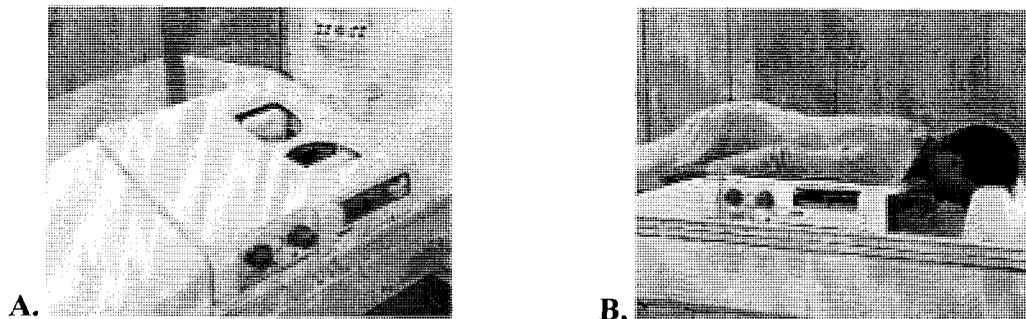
Image A shows a recent advancement in MRI breast imaging, the CP Breast Array Coil. This allows for bilateral breast imaging and improved differentiation between various breast tissues. With image B, the patient is placed directly on top of the table. The technologist has visual control of the breast position through a transparent window (MR Breast 2005).
